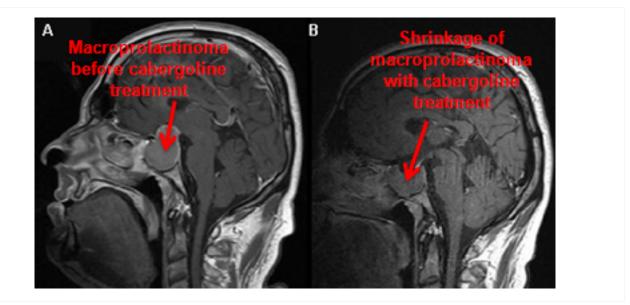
Gadolinium-enhanced magnetic resonance imaging (sagittal view) showing a 40 mm pituitary macroprolactinoma in a 41-year-old man before (A) and after (B) 2-month treatment with cabergoline
